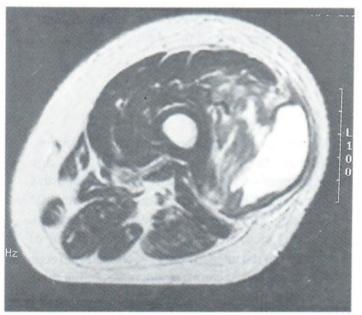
(b) Axial MR image of the left thigh demon - strates a high signal intensity fluid collection in the muscle and increase signal intensity in the adjacent muscle.
